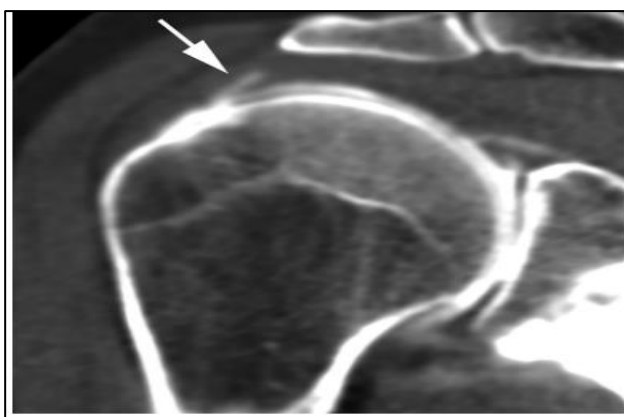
CT arthrography. Coronal reconstruction from CT arthrogram reveals a small partial thickness undersurface tear (arrow).¹⁸
